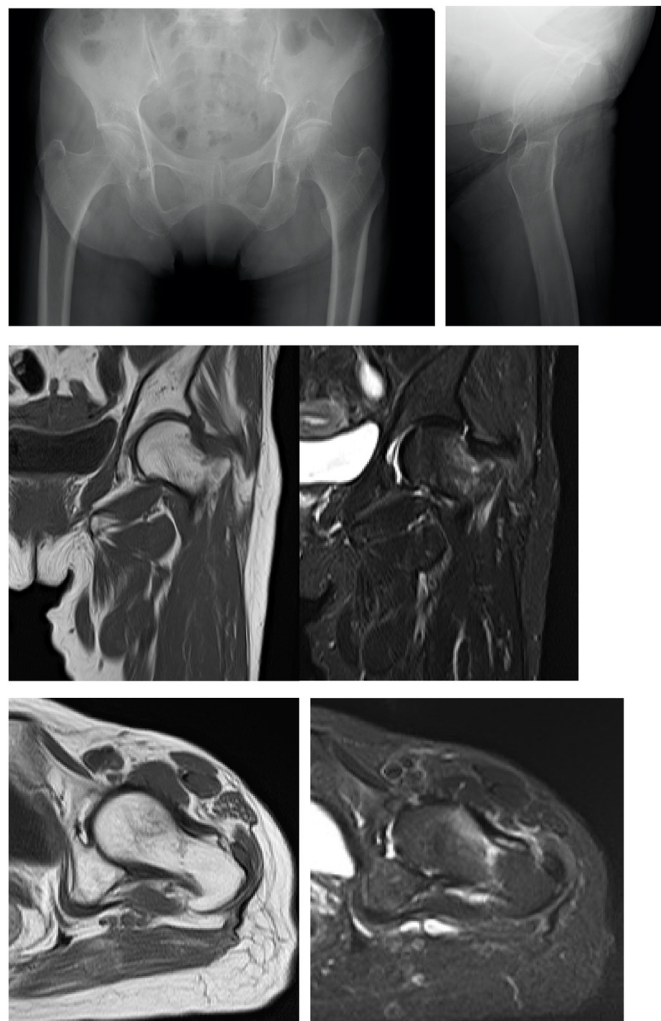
Radiography and MRI in the femoral neck occult fracture.
